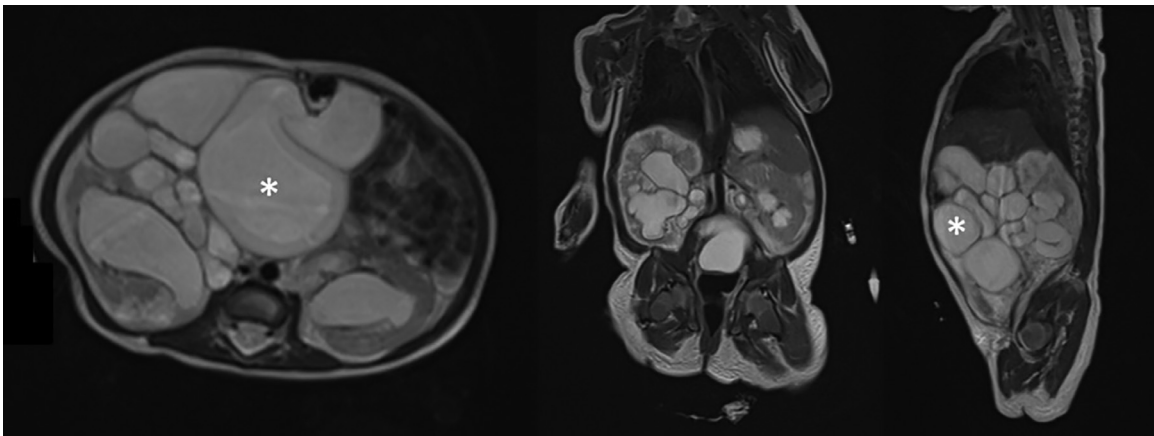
Axial, coronal, and sagittal sections of a T2-weighted MRI showing the duplex right kidney and the mass effect of the dilated tortuous right sided obstructed ureters (asterix on axial and sagittal images).
